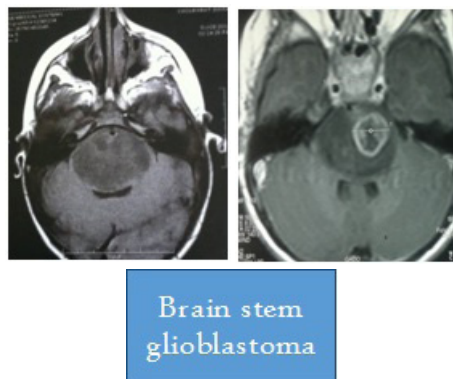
Cerebral MRI of a glioblastoma of the brainstem of a 4-year-old patient operated in 2014 for a glioblastoma of the brainstem, these images show a T1 hyper signal on MRI and a very intense contrast enhancement in peripheral and irregular, she takes a characteristic ring-like appearance around necrotic areas
